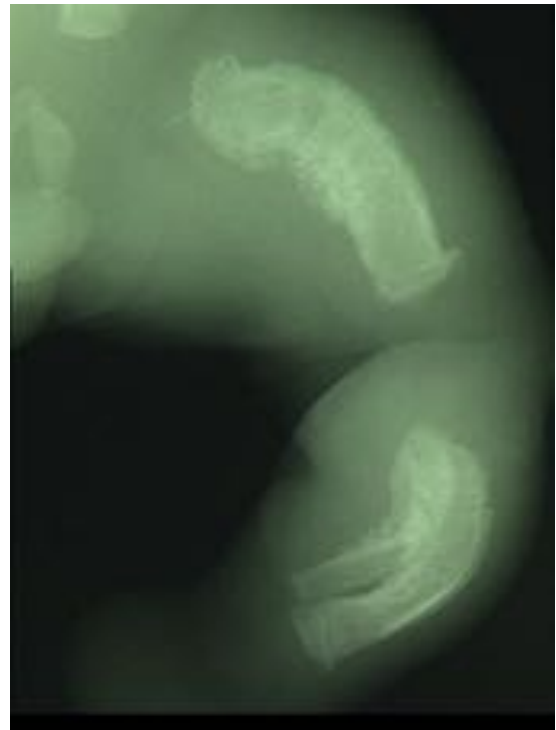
Lower limb radiograph: see the bloated diaphyses of the bones with a double contour of the cortex and the sclerotic bony substance. Femurs, tibiae, fibulae are all angulated.
